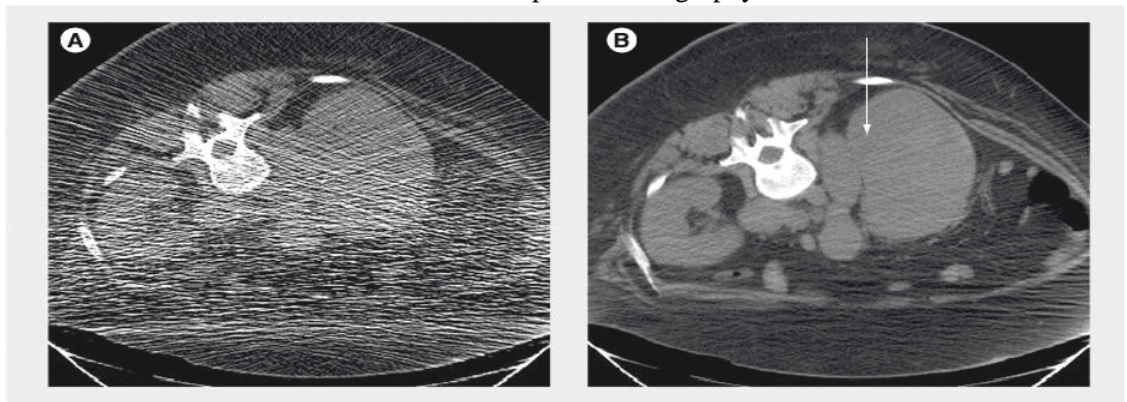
Effect of mA on Poisson noise. (A) Low-dose CT image obtained during a CT-guided biopsy shows extensive Poisson noise (60 mA, 120 kVp, slice thickness 5 mm). These streaks are the same whether or not the abdomen or arms are partially outside the field of view. (B) Postbiopsy image obtained at 7.3-times higher dose has $\sqrt{7.3} = 2.7$ -times less noise (440 mA, 120 kVp, slice thickness 5 mm). The images show an enlarged retroperitoneal lymph node (arrow) and infiltration of the right kidney in a patient with Hodgkin’s lymphoma.
